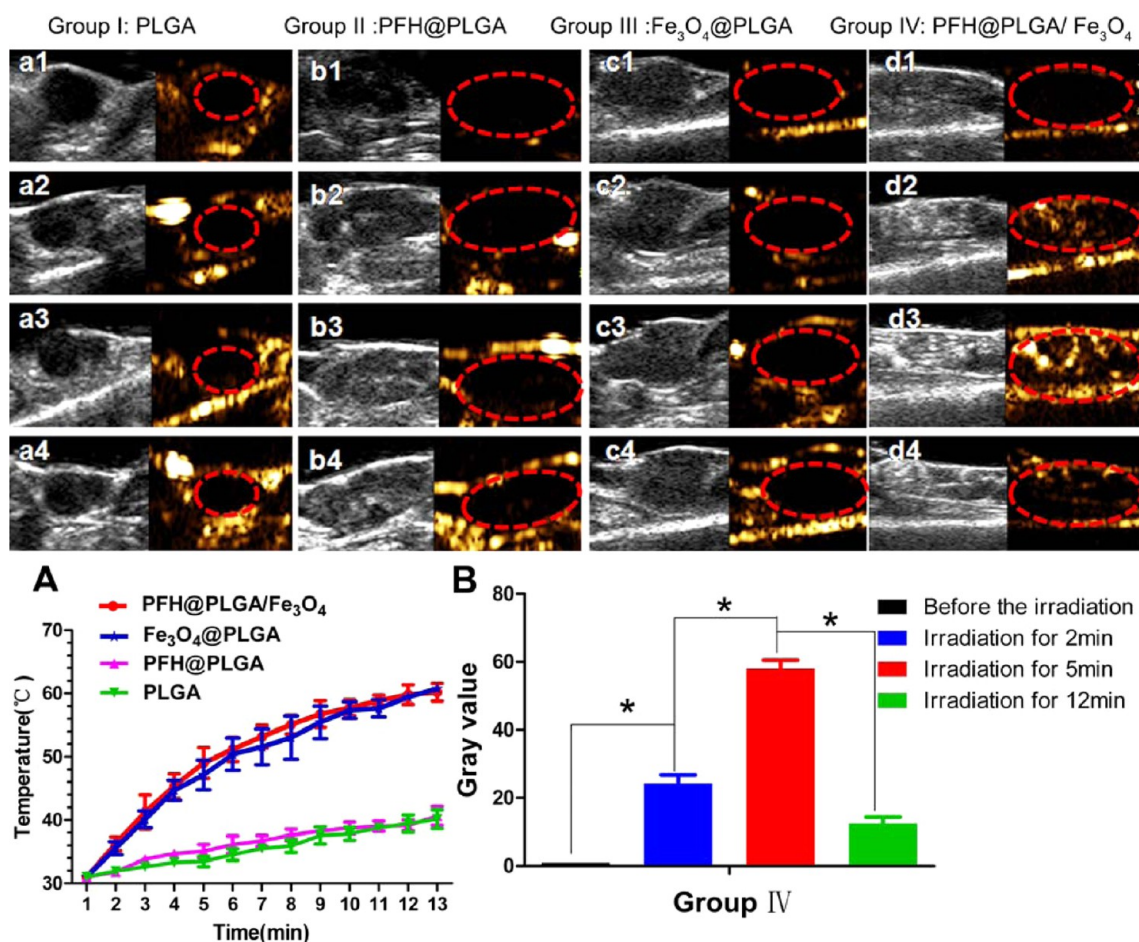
(A) Temperatures of four groups injected with different nanocapsules increased with increasing irradiation time. Four ultrasound images of groups I–IV (a1–d1) before irradiation and after irradiation for (a2–d2) 2 min, (a3–d3) 5 min, and (a4–d4) 12 min (B-mode (left) and contrast-enhanced ultrasound CEUS (right)). The red dotted circles indicate tumor location. (B) Gray value of each ultrasound image in group IV (PFH@PLGA/Fe₃O₄ nanocapsules) (p* < 0.05). An asterisk (*) indicates significant difference between any two images (d1–d4) in the gray value of group IV.
